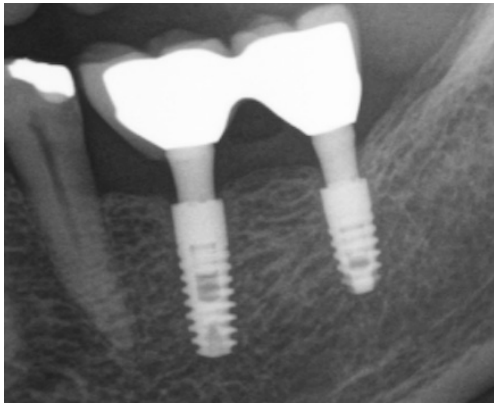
Subcrestal and epicrestal implant placement in the same patient after 3-month healing and one-abutment concept. This radiograph presents the crestal bone stability 25 years after loading.
